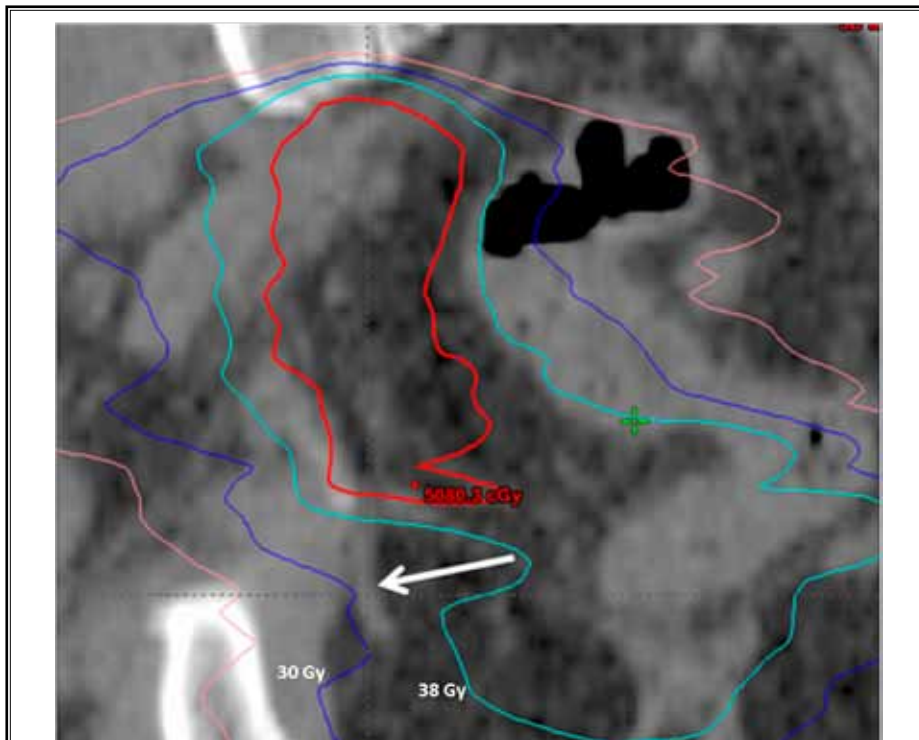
Dose distribution projected on coronal CT image. The pudendal nerve (arrow) is again seen to have received between 30 and 38 Gy (represented by the dark and light blue lines, respectively).
